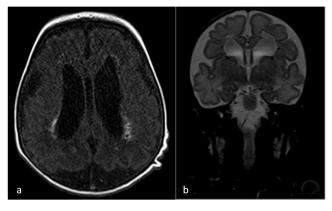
(a, b) Cranial MRI revealed diffuse calcification in the periventricular white matter, hydrocephalus, dilation of the ventricles, and cerebral atrophy MRI: Magnetic resonance imaging
